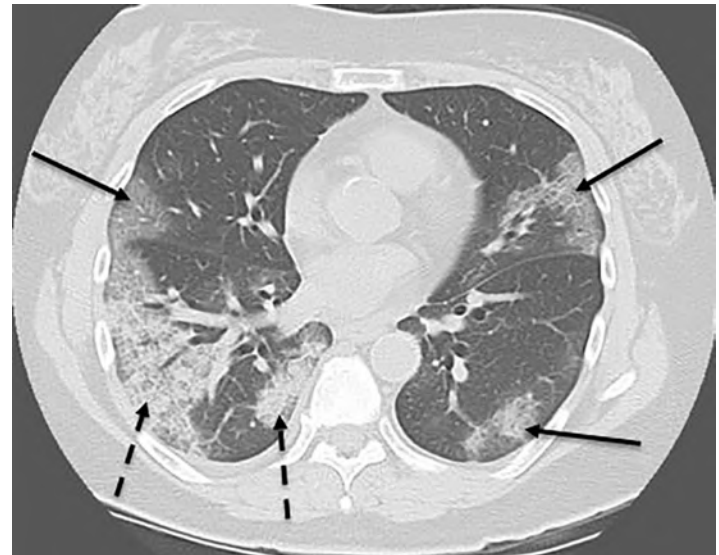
Computed tomography of the chest without contrast in an axial cut showing diffuse multifocal infiltrates (solid arrows) with areas of consolidation and increased infiltrates in the posterior segments (dashed arrows).
